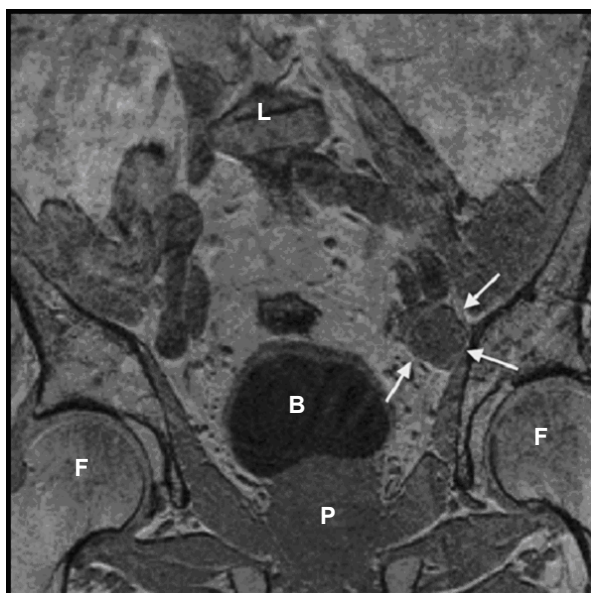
Coronal reconstruction image of the T1-weighted 3-dimensional gradient-echo sequence at 1.5 T (TR/TE: 8.6/ 4.2 milliseconds) showing the single enlarged lymph node (arrows) located ventral of the internal iliac artery. The maximal diameter of the lymph node was 2.5 cm. L, lumbar spine; B, bladder; P, prostate; F, femoral head.
